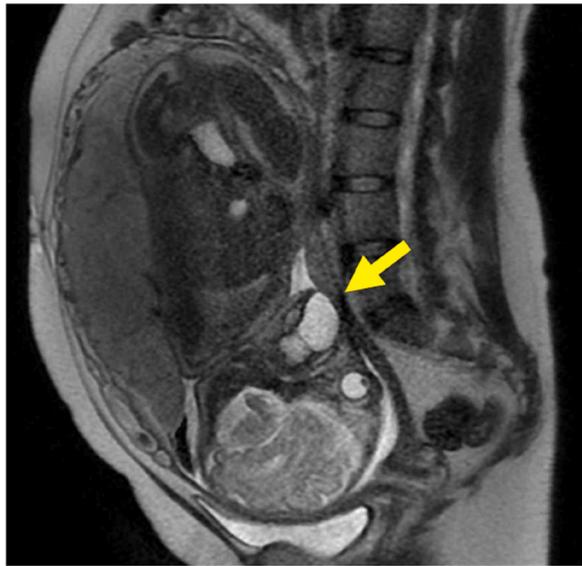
Fetal MRI: MRI at 26 weeks' gestation showing a cystic mass protruding from oral cavity (arrow).
